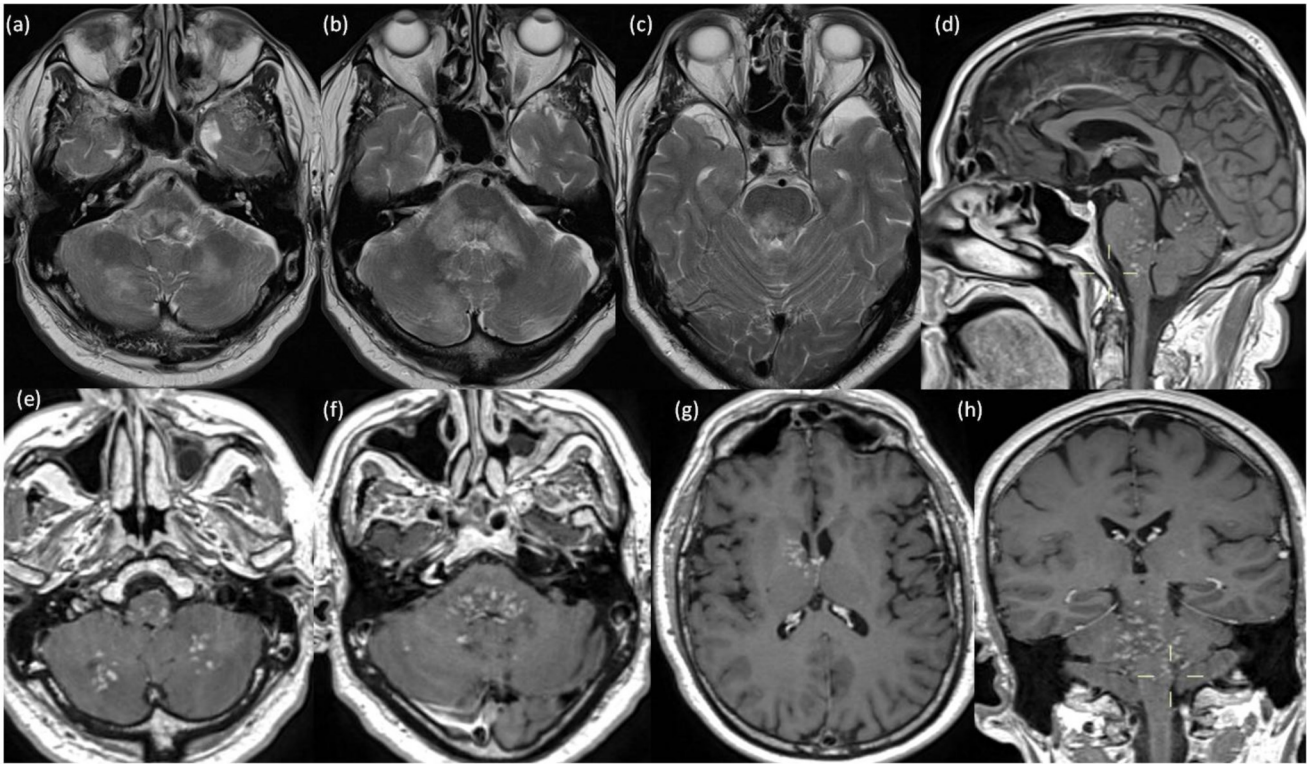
Subsequent MRI at 3 months. T2 axial images through posterior fossa (a-c) and post contrast T1 images (d-h) showing linear and punctate areas of enhancement throughout brainstem, cerebellum and right basal ganglia with associated high T2 signal.
